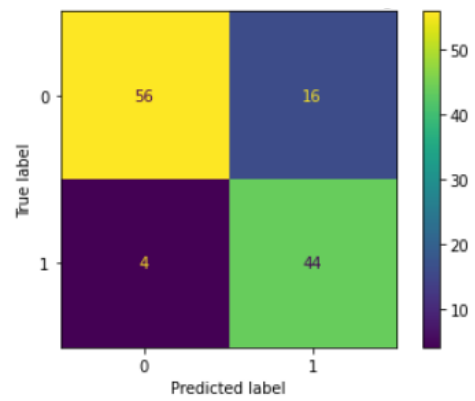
Confusion Matrix CNN+SVM: – CT Scan Image
